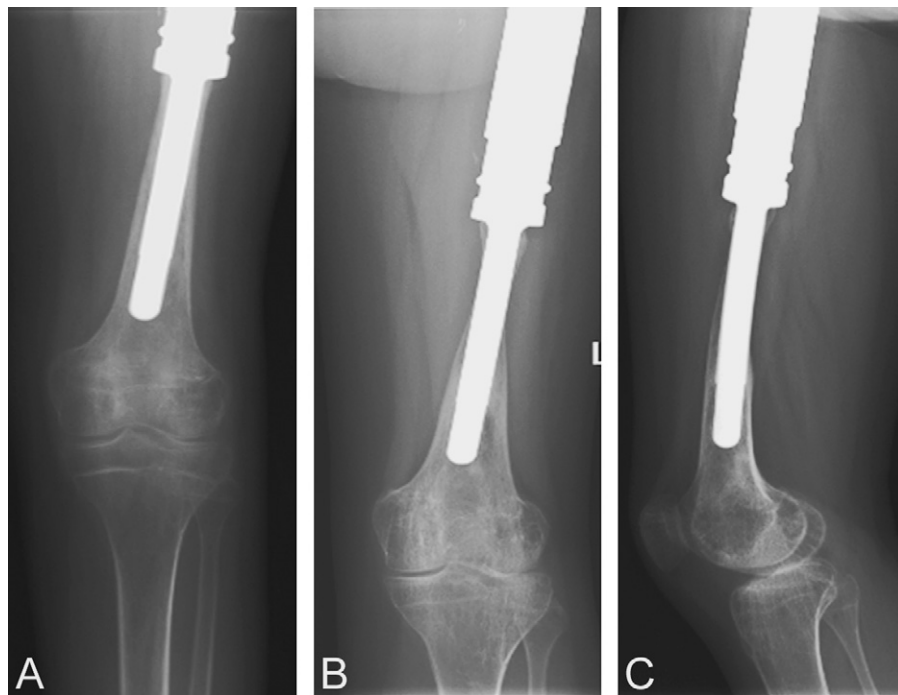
X-rays of the distal femur of a 18-year-old woman, who underwent radical resection and megaprosthesis reconstruction of the left proximal femur due to Ewing's sarcoma at the age of 13. Two years after surgery, the distal femur showed early signs of cortical thinning around the distal prosthetic stem (A). Five years after surgery, there is a major progression of the periprosthetic cortical bone loss due to stress-shielding (B and C). The patient needs bone grafting procedure in order to restore the supporting bone structure and prevent periprosthetic bone fracture.
